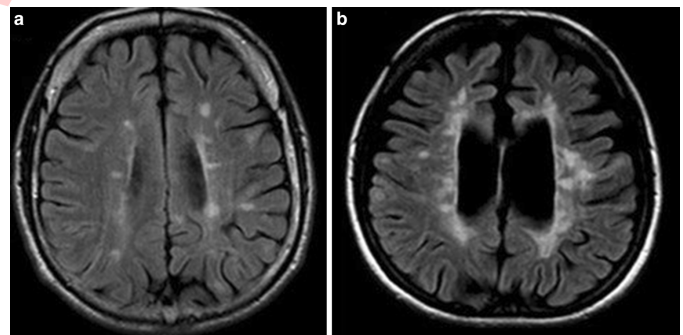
The above images show axial plane brain MRI scans of two atypical PPMS patients who show multiple focal lesions in periventricular, deep and juxtacortical white matter more common in RRMS in addition to brain atrophy. Image source: (Siger 2022), distributed under Creative Commons Attribution 4.0 International License
